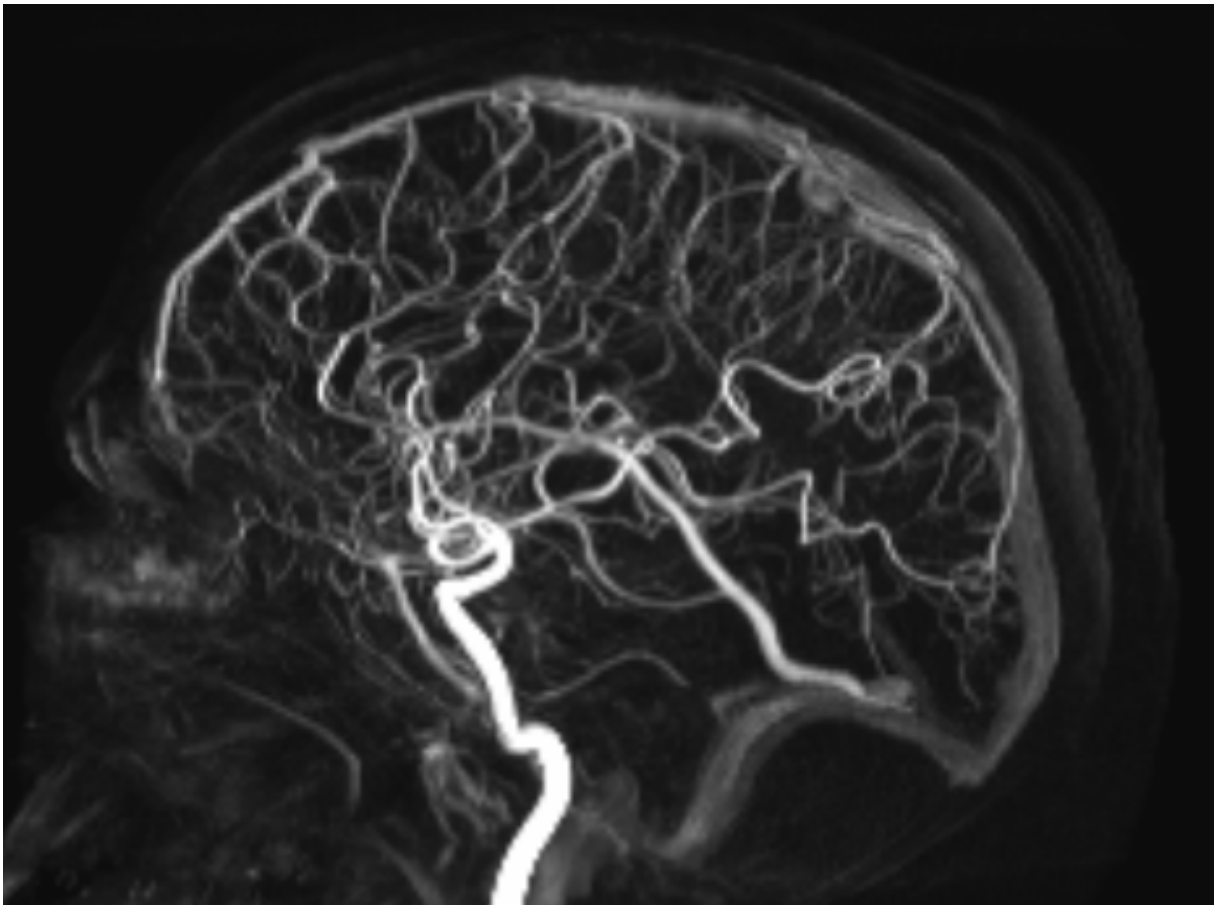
A Digital Subtraction Angiography obtained subtracting the bone mask to the contrast enhanced CBCT reconstruction, obtained with the O-arm4, Medtronic, Minneapolis, Minnesota
